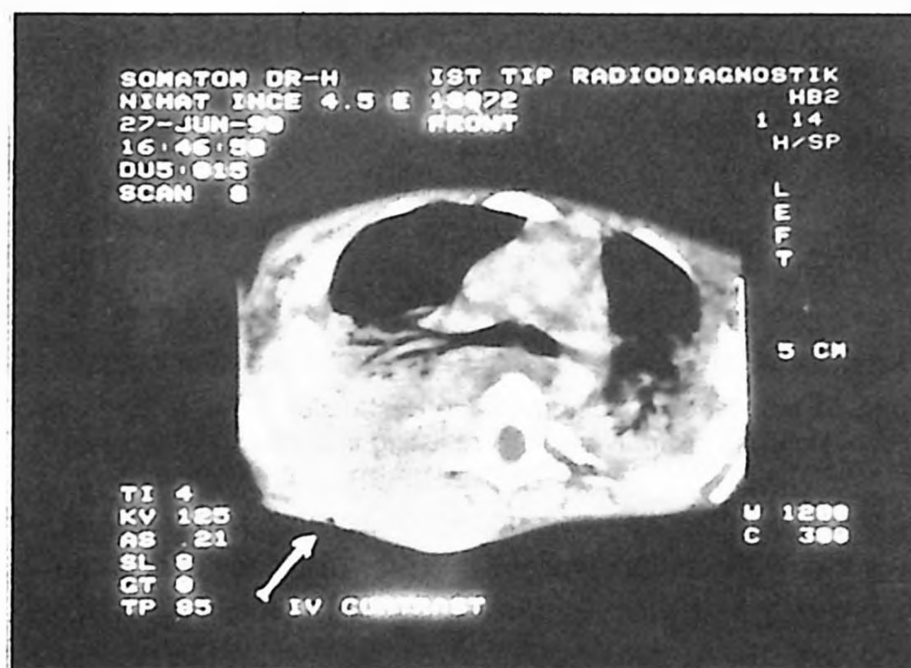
Computed tomography of patient showing the invasion of granulomatous lesions to the lungs, ribs and vertebrae. The external opening of the bronchocutaneous fistula is shown with an arrow.
